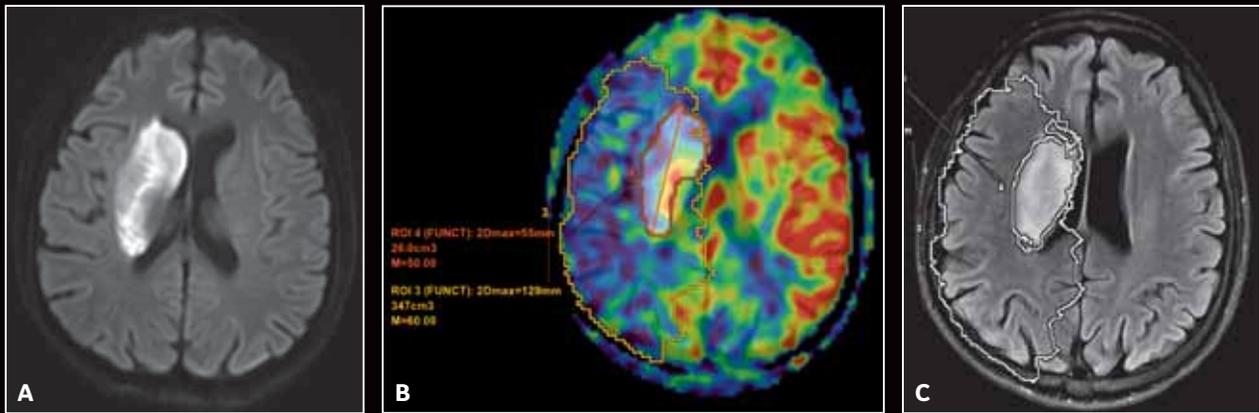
A 35-year-old patient with sudden onset of left-sided weakness. (A) Axial DWI, 160 x 160 in a 48 sec scan time. (B) Fused DWI ASL images showing diffusion perfusion mismatch. (C) ROI overlaid on T2 FLAIR image. ASL was helpful in demonstrating ischemic penumbra noninvasively with color maps and quantified values without the use of contrast.
